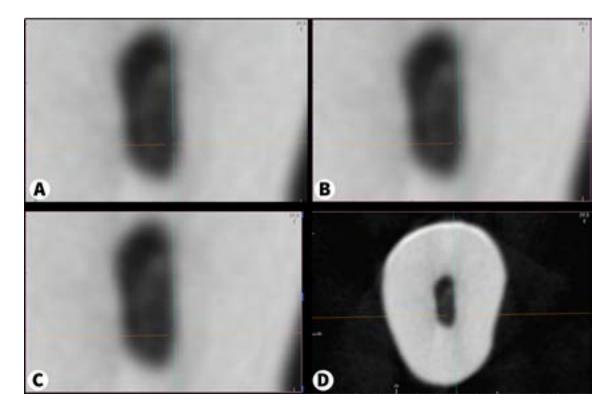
(A-D) CBCT report showing the position which will be measured, and defines the point on the edge of the root canal after adjustment in intermediate position in the grayscale.
